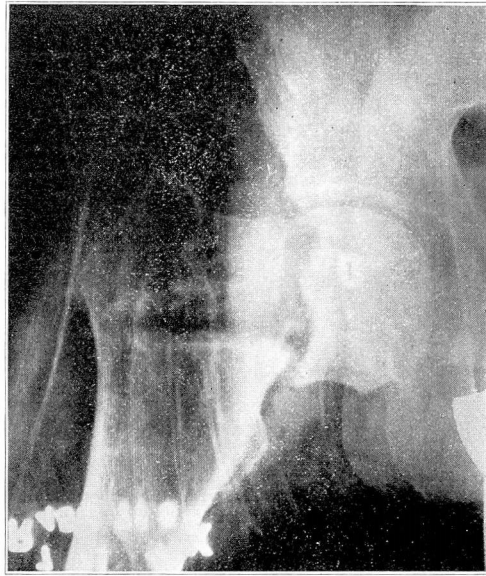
Roentgenogram of typical ununited fracture of femoral neck.
